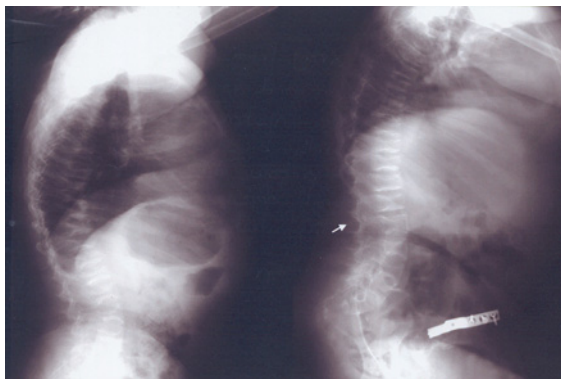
Lateral X-ray film of the lumbar spine of a patient before and after one-year cyclic pamidronate treatment. Collapsed vertebral bodies with biconcave deformities are shown with arrow. A remarkable increase in vertebral corpus height and density was demonstrated.
